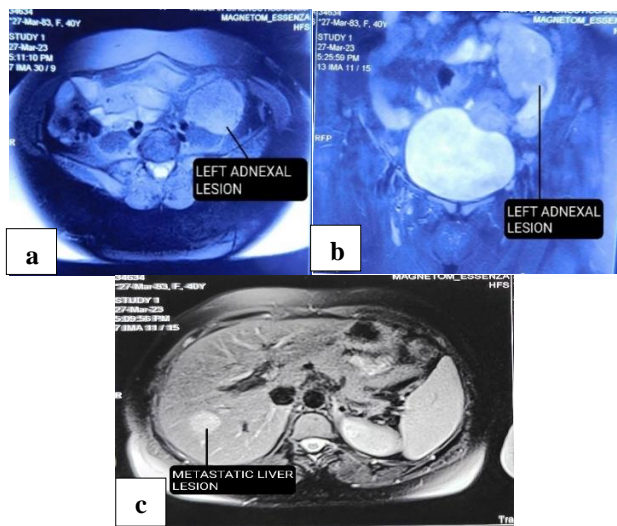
PET – CT showing (a) and (b) adnexal lesion and (c) liver lesion.
